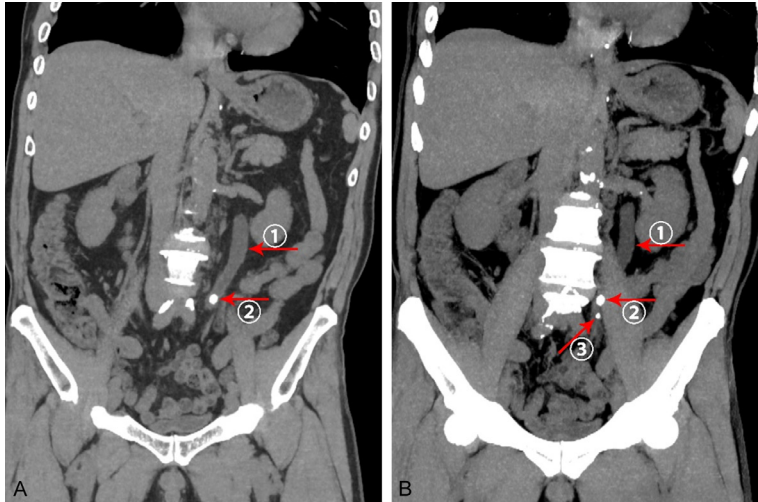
Plain CT tomography was performed on admission. A. ① Left ureteral dilatation; ② Ureteral calculi. B. ① Left ureteral dilatation; ②, ③ Ureteral calculi. CT, computed tomography.
